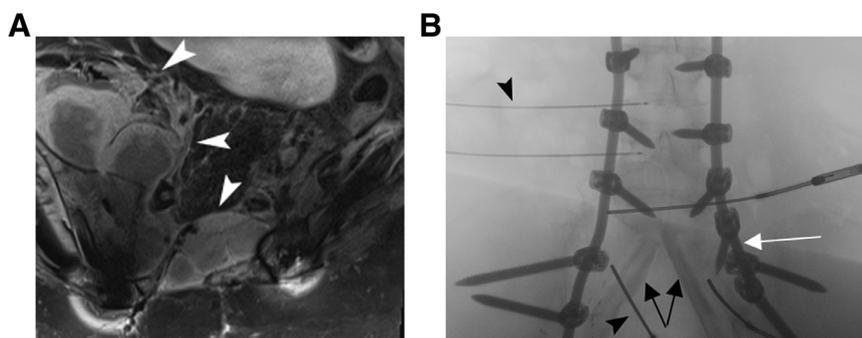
A 14-year-old girl with Ewing sarcoma with painful osseous metastases of the pelvis and lumbosacral spine presented seeking palliative treatment for pain related to compression of lumbosacral nerves. Axial T2-weighted image of the pelvis (A) shows an aggressive soft tissue mass involving the right iliac bone and sacrum (arrowheads). An intra-procedural AP fluoroscopic image shows 5 cryoprobes (arrowheads) within the soft tissue mass adjacent to lumbosacral nerves. Also noted are hardware from prior spinal fusion (white arrow) and fibular bone grafts (black arrows) placed during sacral resection.
